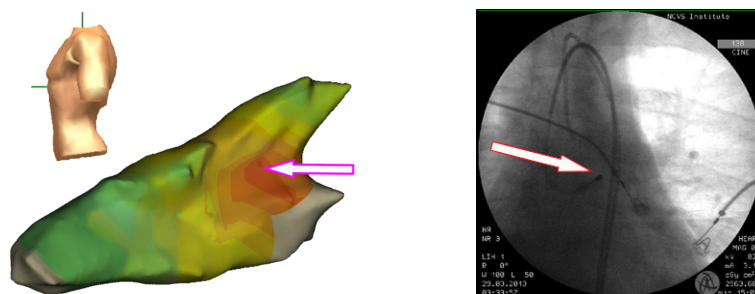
Initial ectopic activation sites obtained from the EPS: from the navigation system during intracardiac mapping in patient P1 (left) and from the X-ray image as the position of the ablation electrode tip in patient P2 (right).
